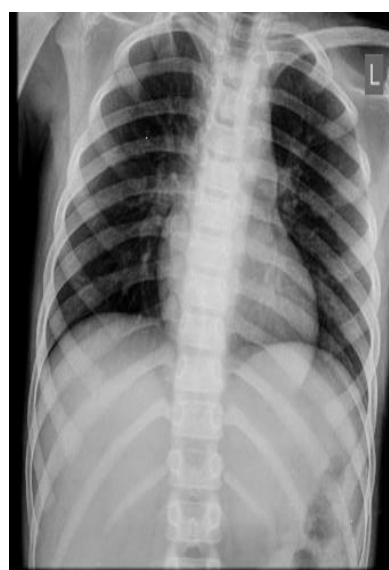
Chest X-ray after three days of bronchoscopy shows normal findings.
